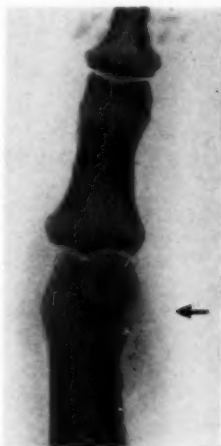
Postero-anterior roentgenogram of the phalanges of the right index finger. There is a small circular radiolucent defect on the ulnar border of the distal end of the proximal phalangeal shaft. The thin overlying cortex is unbroken and is raised like a blister. The bone immediately adjacent to this area is somewhat decalcified. The ulnar border of the phalanx, for about one centimeter proximal to the rarefied defect, is irregular, and at one point a definite groove is demonstrable.
